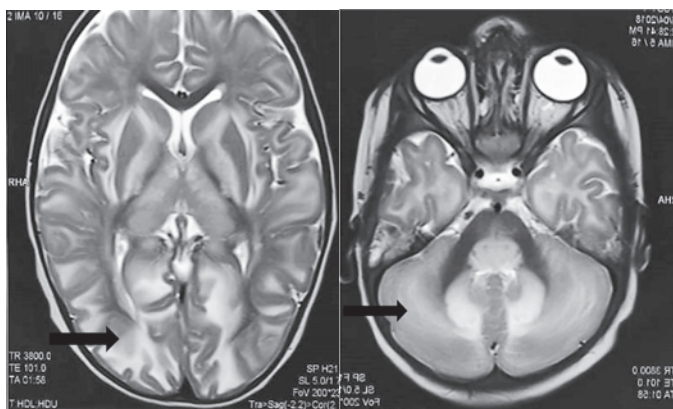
T2 weighted MRI images show hyperintensity in cerebral white matter, cerebellar dentate nuclei (Black arrows).
